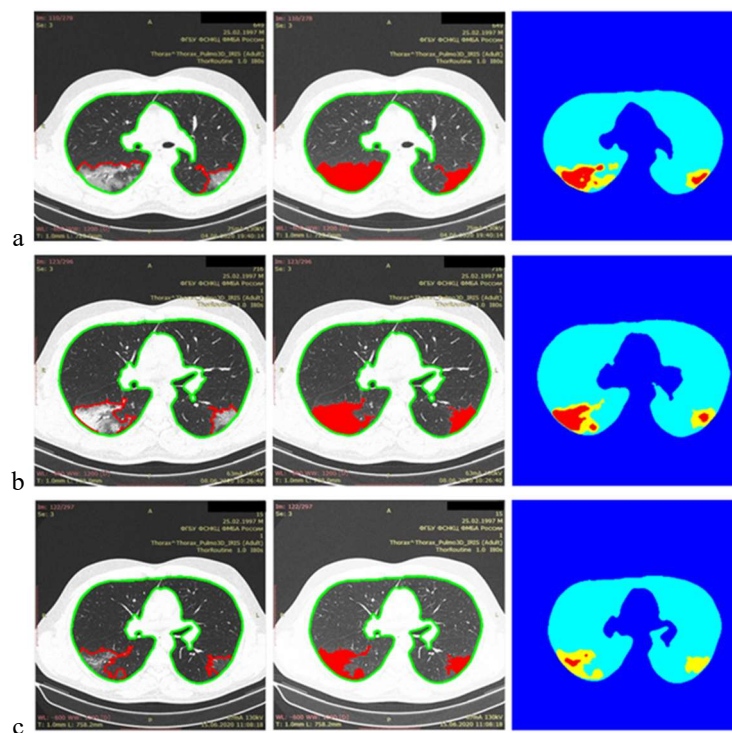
Examples of the CT image processing of the lungs with COVID-19: (a) follow-up on day 3 of the disease; (b) follow-up on day 7 of the disease; (c) follow-up on day 14 of the disease.
